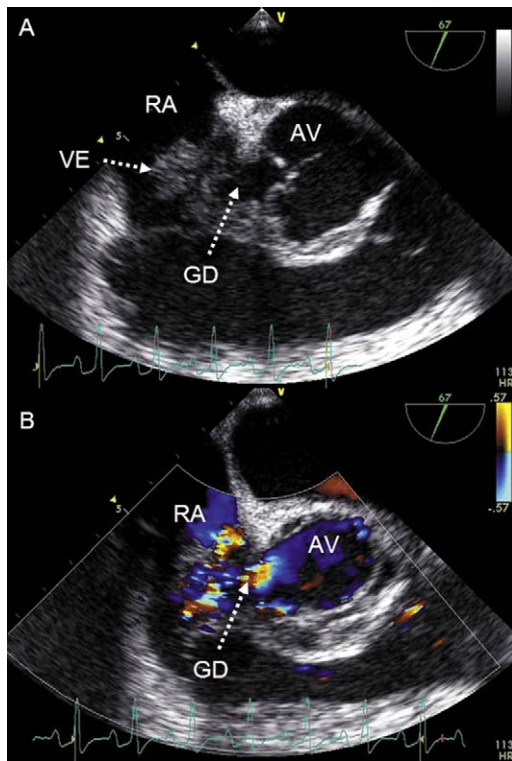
Multiplane TEE without (A) and with colour Doppler (B) demonstrate the large left ventricle to right atrial communication (Gerbode defect), with vegetations at the base of the tricuspid septal leaflet. AV, aortic valve; GD, Gerbode defect; RA, right atrium; VE, vegetation.
